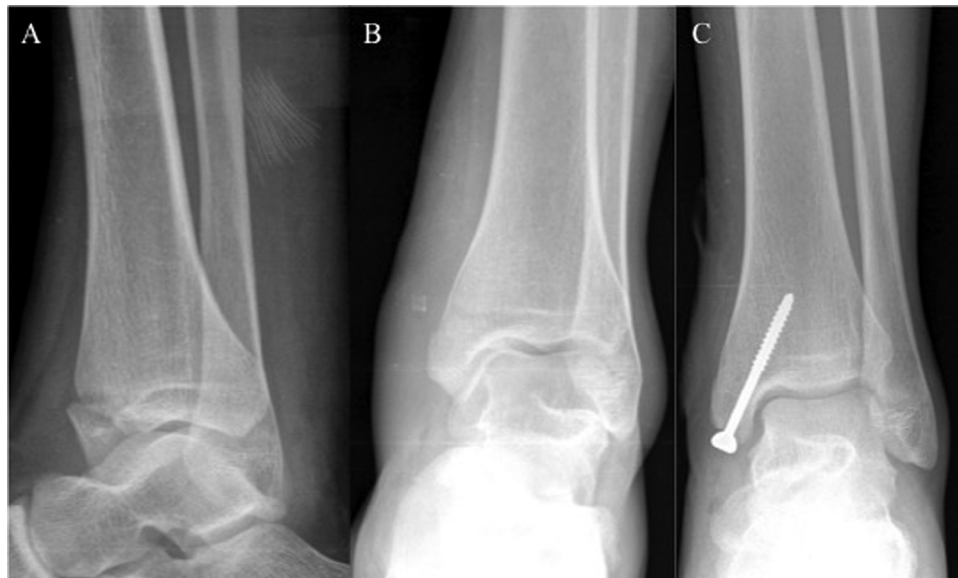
Preoperative (A) lateral and (B) anteroposterior radiograph of an isolated medial malleolar fracture. (C) Postoperative radiograph of the patient treated with 1 cancellous lag screw.
